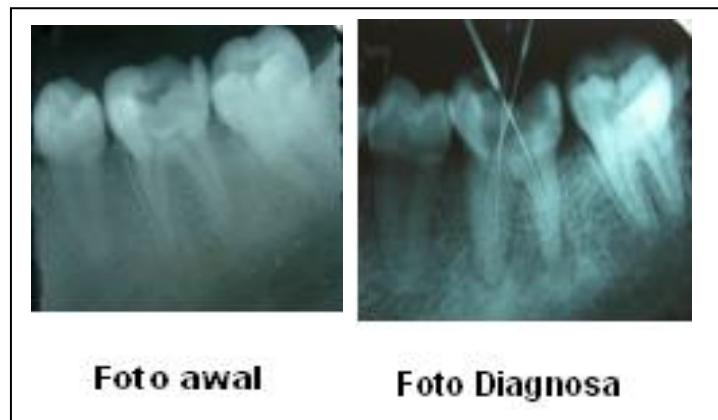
x-ray of first molar
